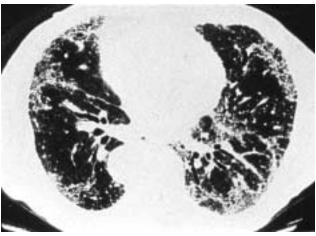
These high-resolution computed tomographic scans show a reticular pattern with a predominantly subpleural distribution in a patient with mid- to late-stage idiopathic pulmonary fibrosis. Septal thickening and honeycombing are also seen.
